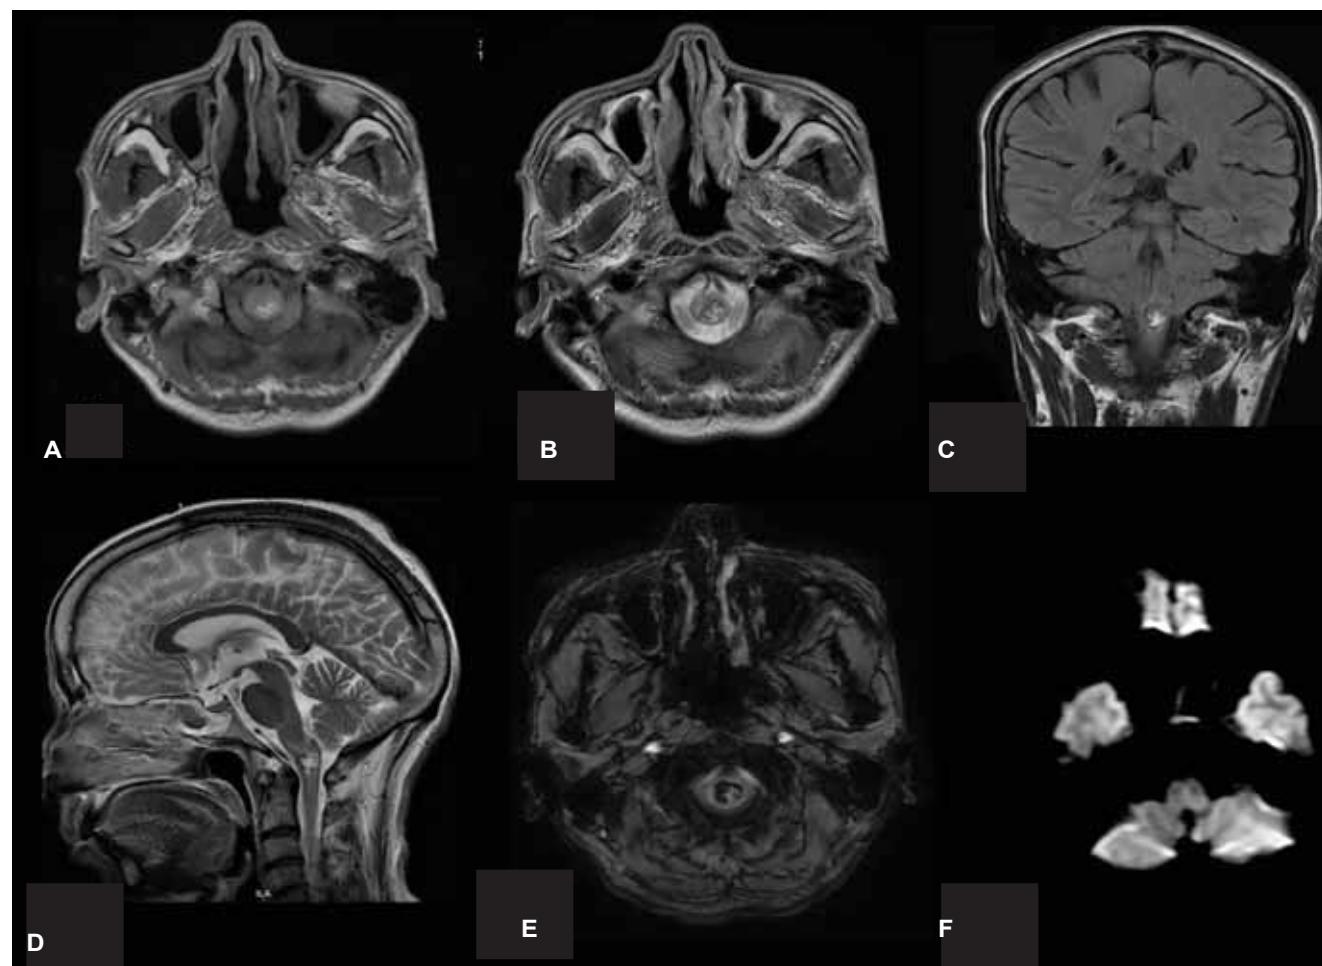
Axial T1W image (A), Coronal FLAIR image (C), showing hyperintense lesion in lower medulla and cervicomедullary junction. On T2 weighted axial (B) and Sagittal (D) images the lesion is hyperintense and is showing peripheral hypointense hemosiderin rim, perilesional vasogenic edema was also seen. On susceptibility weighted images lesion is showing peripheral blooming (E). There was no restriction seen on diffusion weighted image (F).
